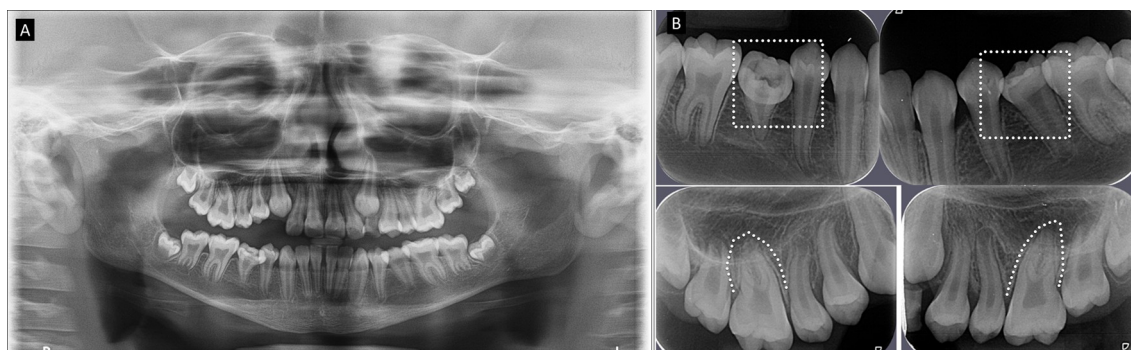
(A) Panoramic radiography. Atypical pattern of dental rhizolysis in deciduous teeth, delayed eruption and development of permanent teeth, crown alteration in #45 and #35, with anomalous morphology (Hutchinson-like) and taurodontics pulp chambers in molars; Increased vascular-nervous caliber in the mandibular canal; sparse medullary mandibular bone trabeculae and thinning of the basilar mandibular. (B) Periapical images highlighting anomalous morphology of #45 and #35 and focal widening of the periodontal ligament space.
